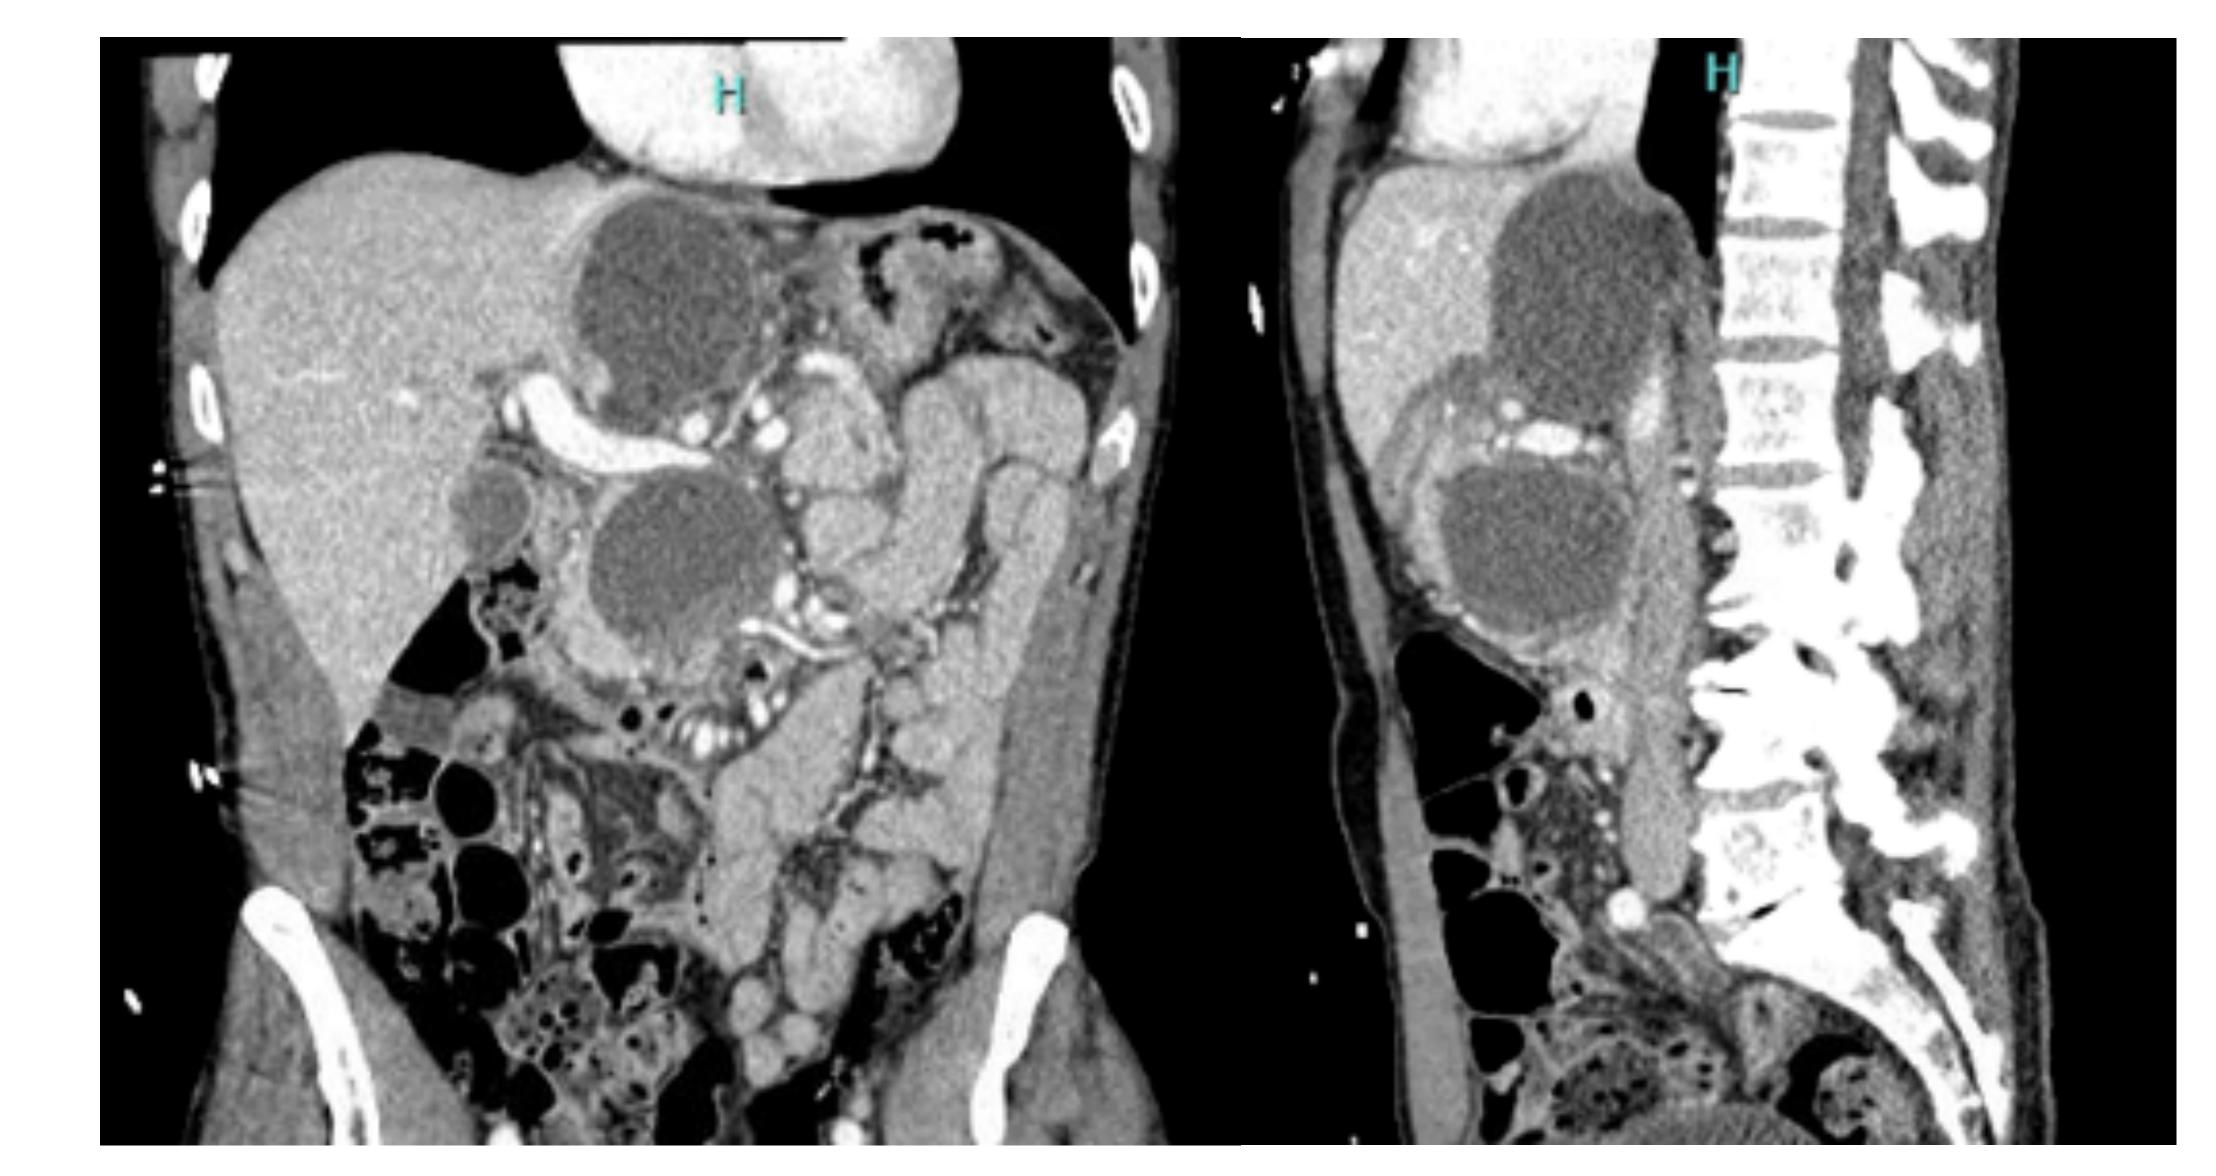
Contrast enhanced CT showing new evidence of hemorrhage into the inferior pseudocyst (left) and severe superior mesenteric vein (SMV) compression by superior pseudocyst (right).
